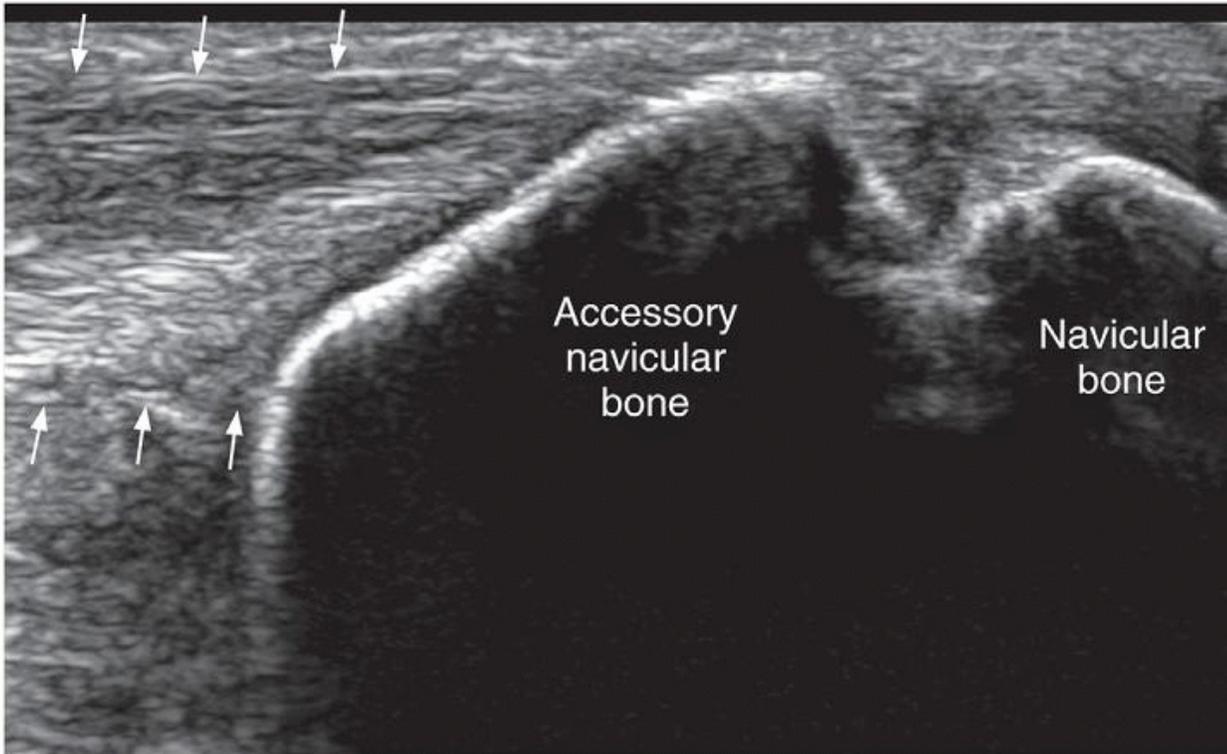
Longitudinal ultrasound medial aspect of the midfoot showing a quite large accessory navicular bone with attached posterior tibialis tendon (arrows) fibers. The junction with the main navicular bone is also shown.
